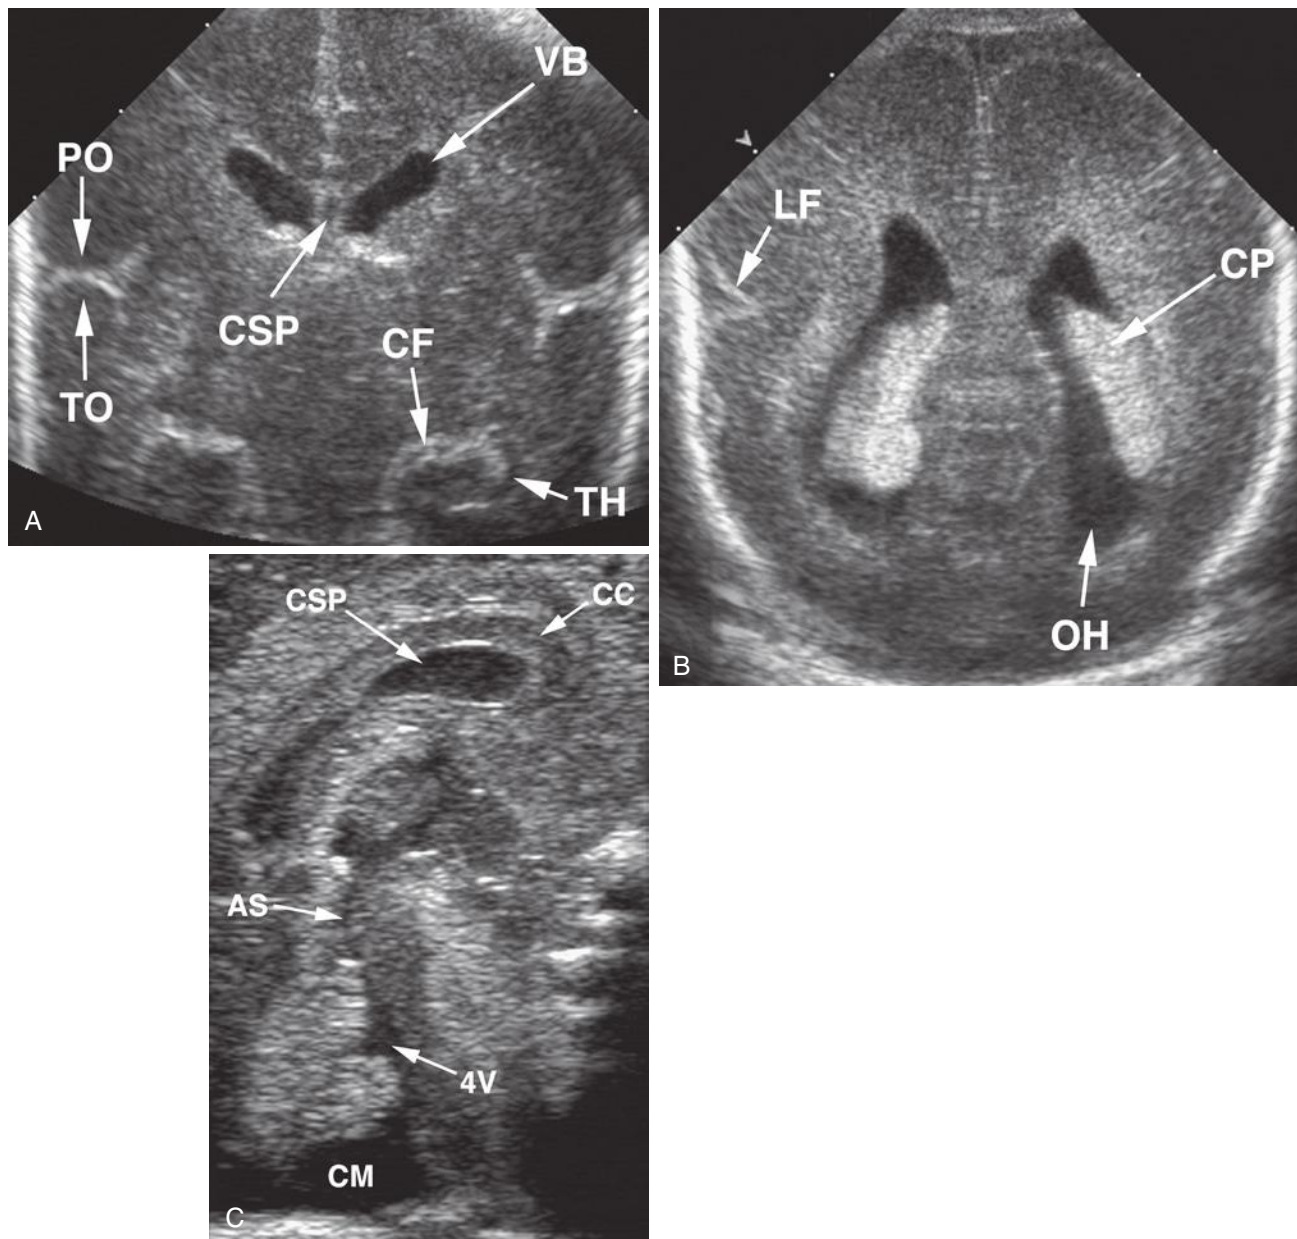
Neonatal head sonograms. Coronal (A), axial (B), and midsagittal (C) images enable correlation with fetal examinations. AS, sylvian aqueduct; CC, corpus callosum; CF, choroidal fissure; CM, cisterna magna; CP, choroid plexus; CSP, cavum septi pellucidum; LF, lateral fissure; OH, occipital horn; PO, parietal operculum; TH, temporal horn; TO, temporal operculum; VB, lateral ventricular body; 4V, fourth ventricle.
